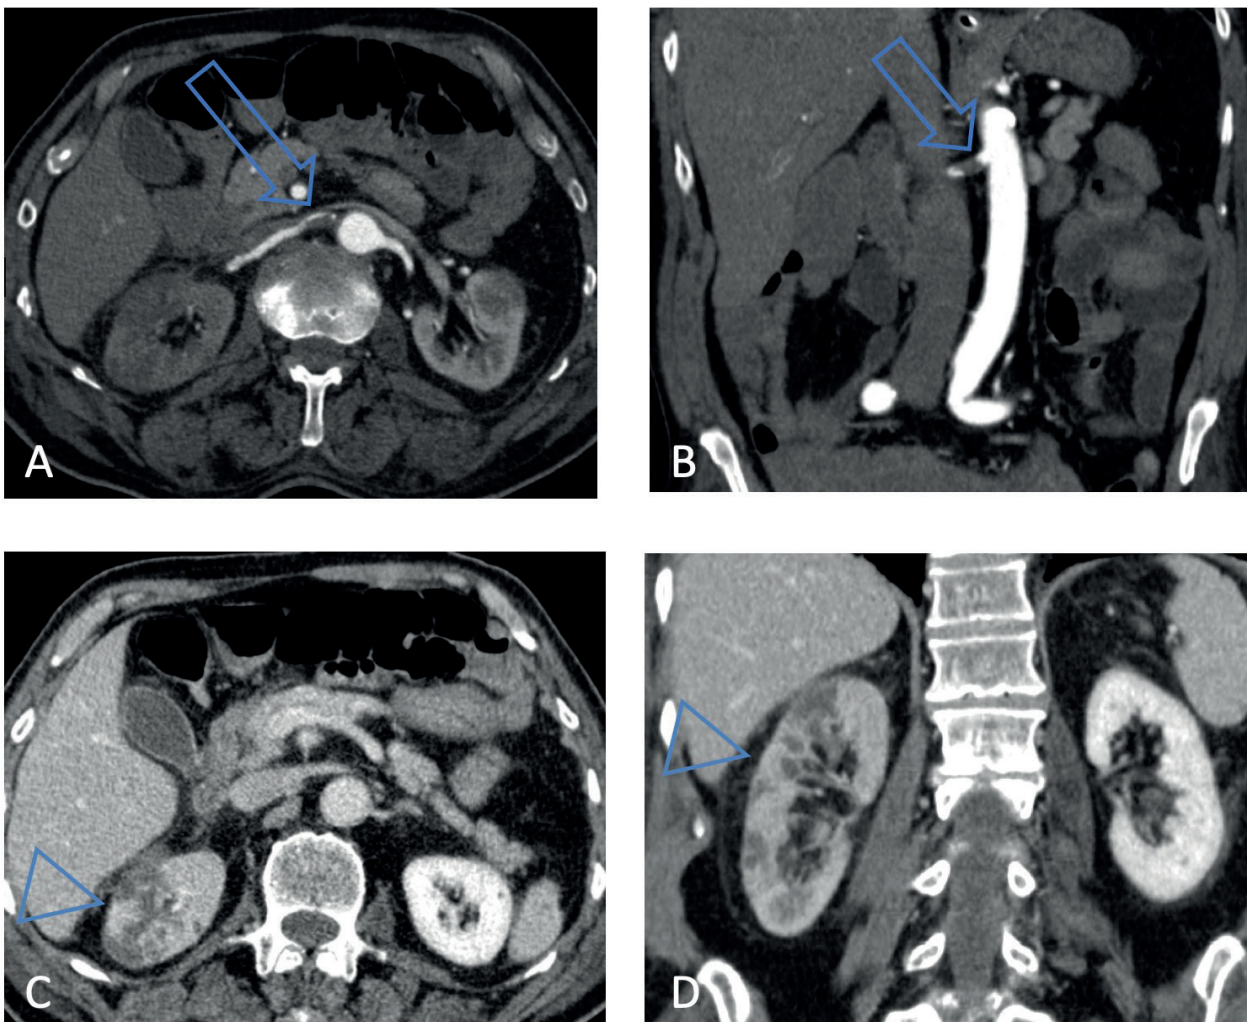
CTA of the abdomen performed after 7 days. Arterial phase showing the maintenance of the right renal artery thrombosis in axial (A) and coronal (B) multiplanar reconstruction (arrows). Venous phase axial (C) and coronal (D) multiplanar reconstruction showing the improved vascularization of the right renal parenchyma (arrowheads).
